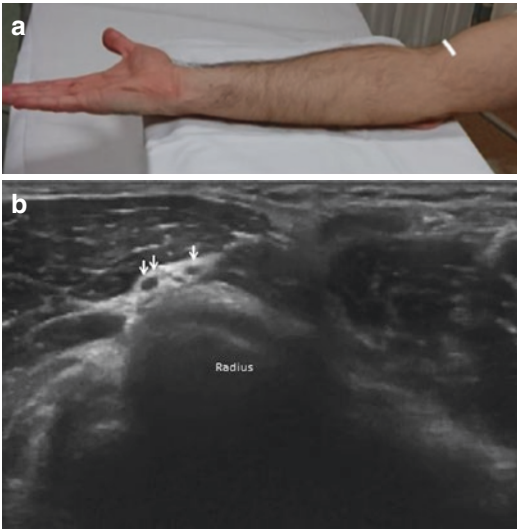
Radial nerve. Transducer placement (a). In the anterior part of elbow (b), the cutaneous sensory branch (arrow) and the posterior interosseous nerve (double arrows), a result of bifurcation of the nerve, can be appreciated with sonography. The two branches are evaluated on short-axis planes
